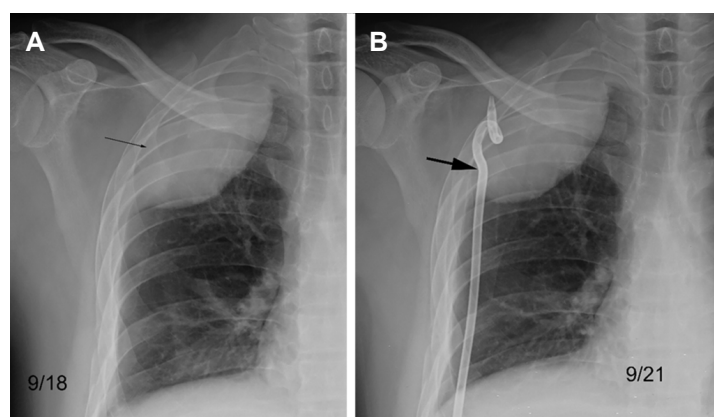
(A) Chest X-ray image reveals a huge hematoma or haemothorax shadow which crosses as many as 4 intercostal spaces. (B) The arrow points out the insertion site of the pigtail tube, which is very close to axillary artery
